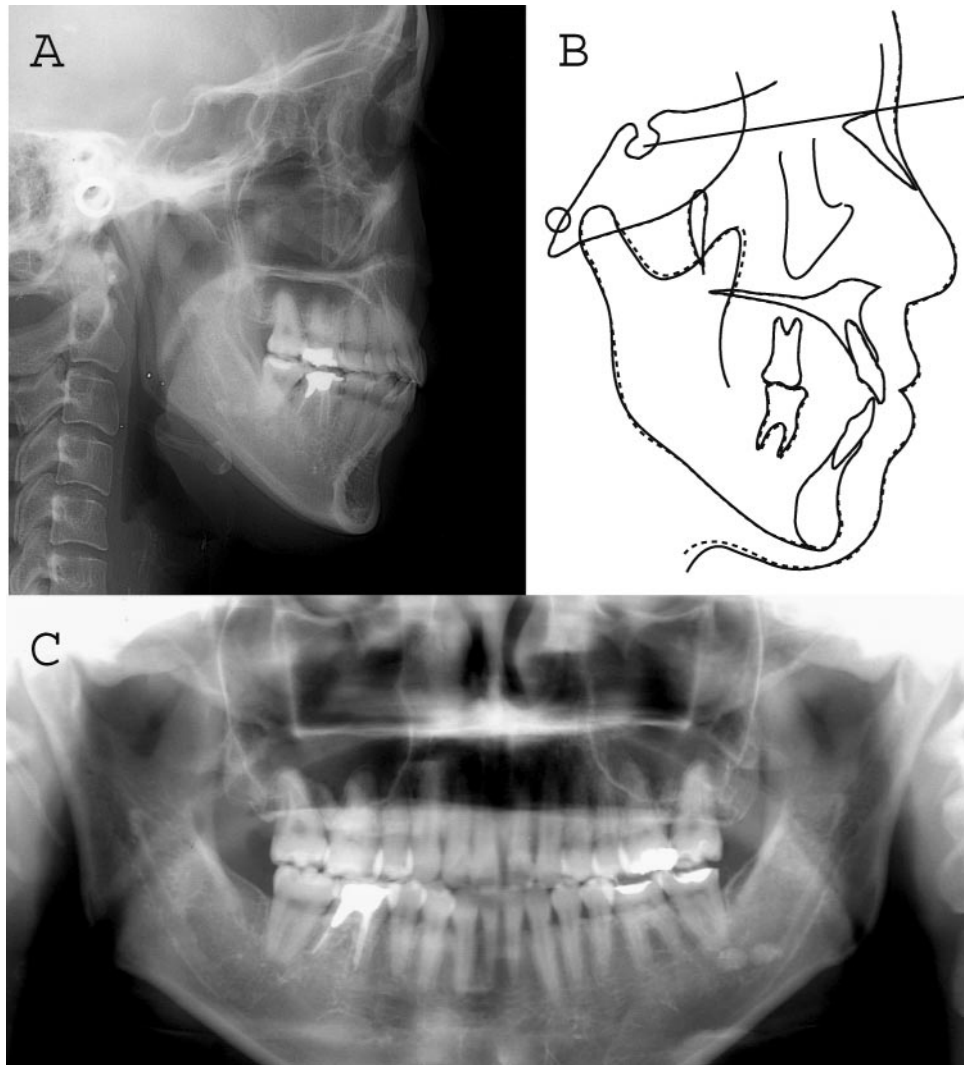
(A) One-year postretention cephalograph. (B) Superimposition of cephalometric tracing. (C) Panoramic radiograph. Tracing (solid lines) was superimposed with posttreatment tracing (dotted line) on the Sella-Nasion plane at Sella.
